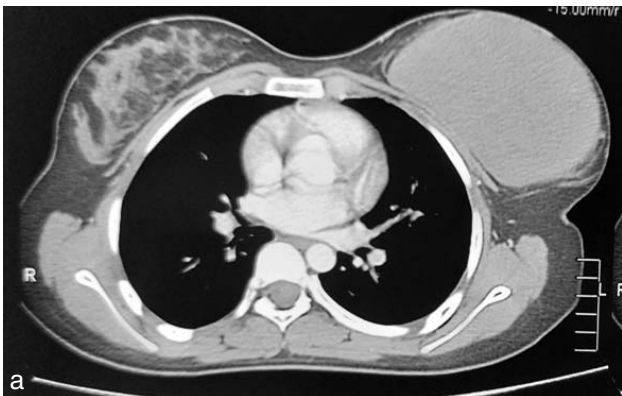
Axial and sagittal images of CT Scan showing a large enhancing lesion in left breast
